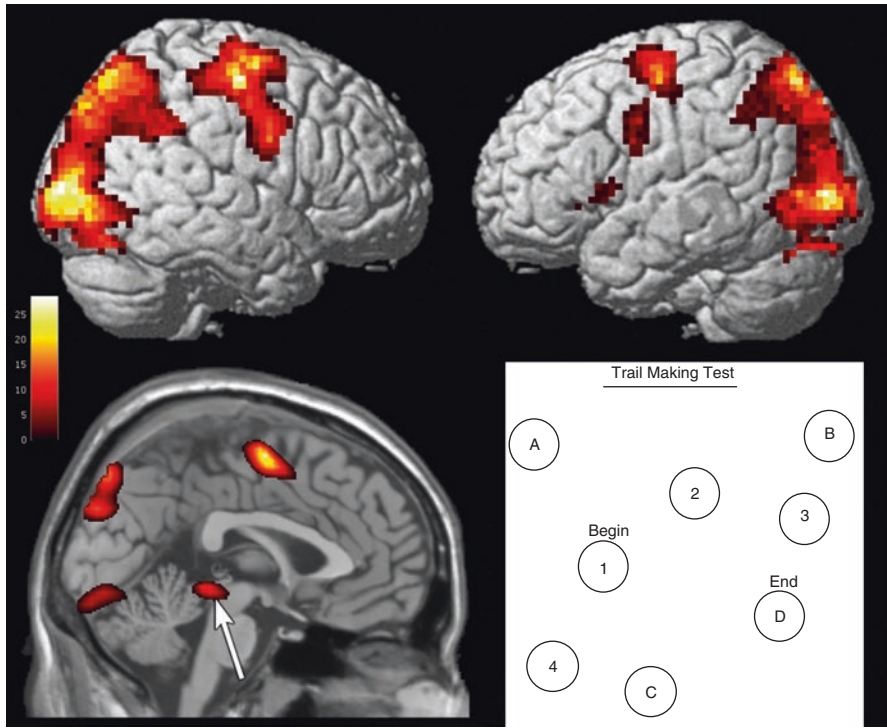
Functional MRI where the BOLD signal of main activation during performance of the Trail Making Test is plotted. A prototype example of the Trail Making Test is shown in the lower right. Arrow points to activation at the level of the superior colliculus
